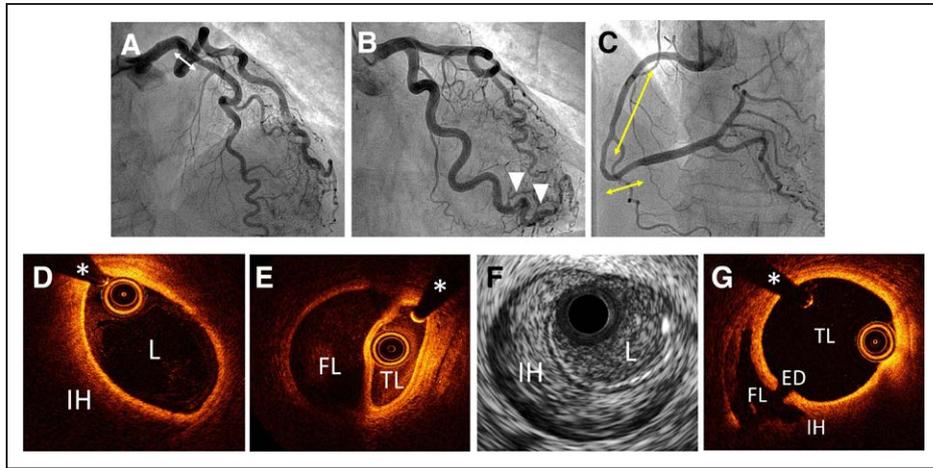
A, Cranial projection of left anterior descending coronary artery (LAD) depicting a mild proximal lumen narrowing (double-head white arrow). B, Caudal projection showing persistence of a double-lumen image (white arrowheads) at the distal portion of left circumflex coronary artery (LCX). C, Cranial projection demonstrating a long segment of mild diffuse narrowing at the proximal and mid right coronary artery (RCA; limited by the yellow lines). D, Optical coherence tomography (OCT) run at the proximal LAD disclosing an image suggestive of intramural hematoma (IH) that displaces the lumen (L). E, OCT at distal LCX shows a double-lumen pattern suggesting nonsealed chronic spontaneous coronary artery dissection (SCAD). F, Intravascular ultrasound at the mid-segment of the RCA showing an IH involving 3 quarters of the circumference of the true lumen. G, OCT was able to identify the entry door (ED) of the dissection at the mid-distal segment of RCA. FL indicates false lumen; and TL, true lumen. *denotes wire artifact.
